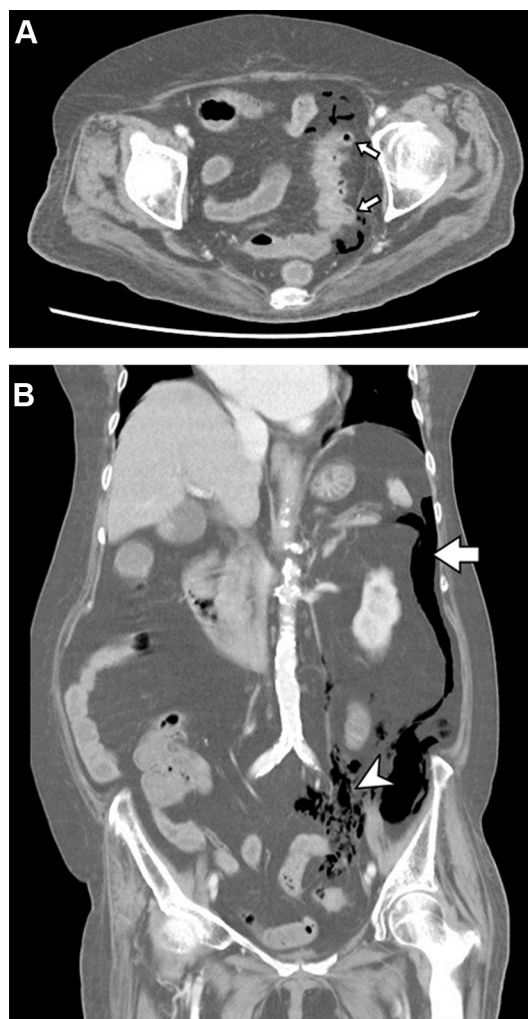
(A) Transverse view of abdominal computed tomography shows multiple outpouching structures (arrows) along sigmoid colon with adjacent fat stranding. (B) Coronal view of abdominal computed tomography shows significant pneumoretroperitoneum (arrow) and pneumoperitoneum (arrowhead).
